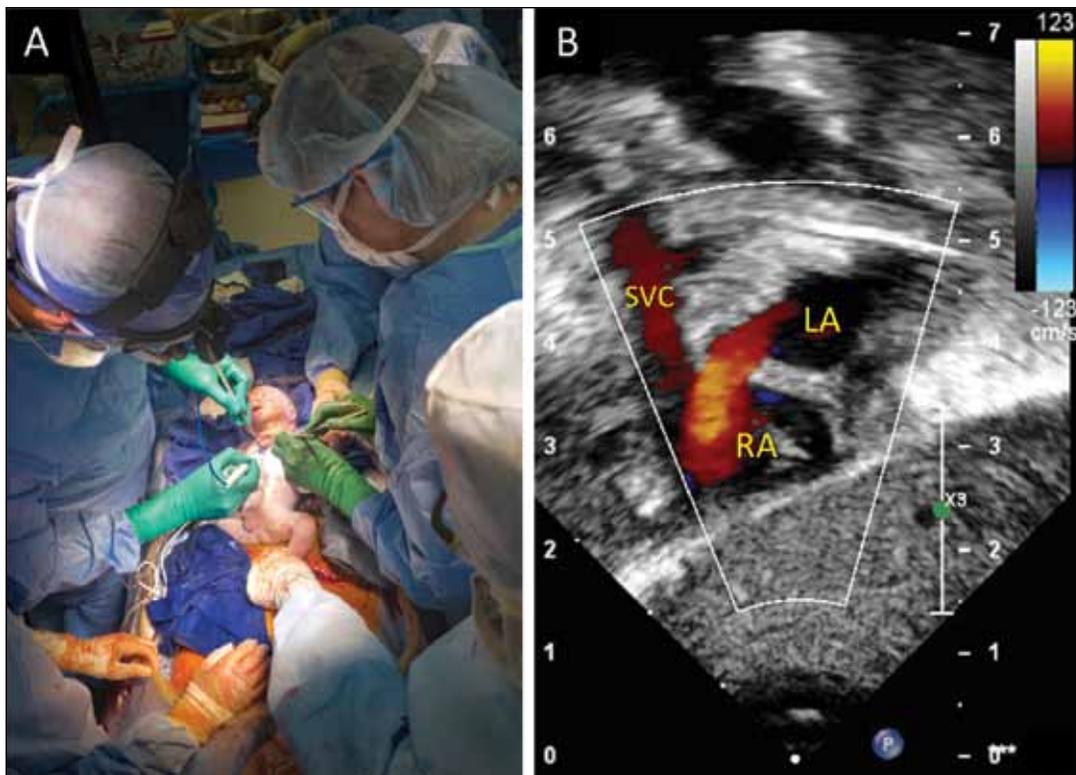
EXIT to surgical atrial septectomy. A, The fetus is lying on the mother's thighs while still attached to the mother via umbilical cord, and the cardiac surgical team is proceeding with atrial septectomy. B, Postoperative subcostal echocardiographic image showing surgically created interatrial communication between the left atrium (LA) and the right atrium (RA). SVC, superior vena cava.
